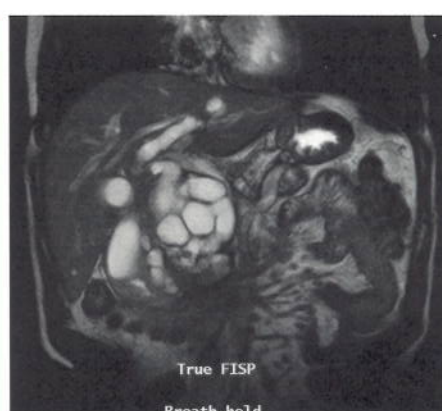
True FISP technique for breathhold T2-weighted abdomens and spines.
